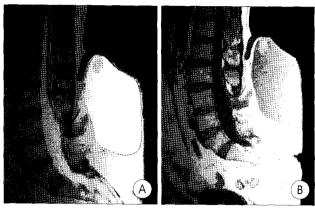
Magnetic resonance image showing lipomyelomeningocele and high signal intensity on the T2 weighted image (A). The mass is is or low signal intensity on the T1 weighted image. There is no evidence of a connection between the mass and any spinal canal component (B).
